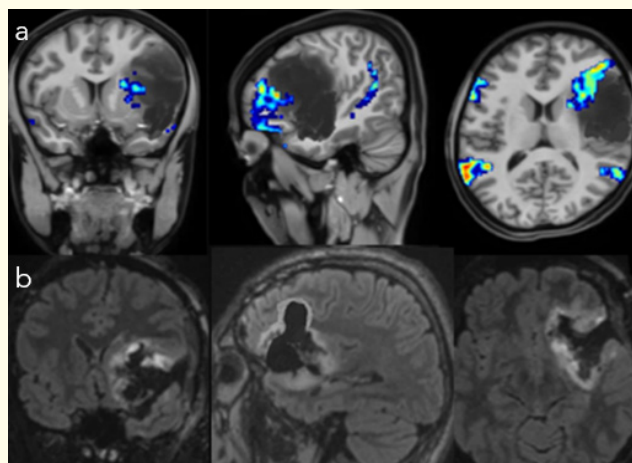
a- Left insular glioma with language parcellations, b- post operative MRI images showing near total excision.
